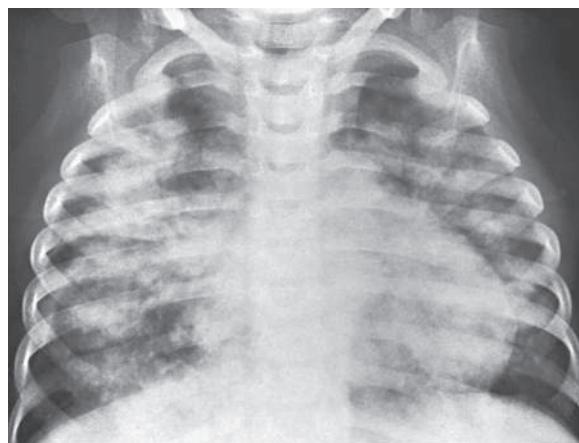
Diffuse pulmonary hemorrhage that was thought to be the result of idiopathic pulmonary hemosiderosis in a 3-yr-old child. Frontal radiograph reveals bilateral air space consolidation that is patchy. Tracheal washing contained large numbers of macrophages filled with hemosiderin. Ten days later, most of the consolidative changes in the lungs had cleared. The patient's anemia was successfully treated with blood transfusion. (Courtesy Bertram Girdany, MD, Pittsburgh, PA; from Slovis T, ed. Caffey's Pediatric Diagnostic Imaging, 11th ed. Philadelphia: Mosby; 2008.)
